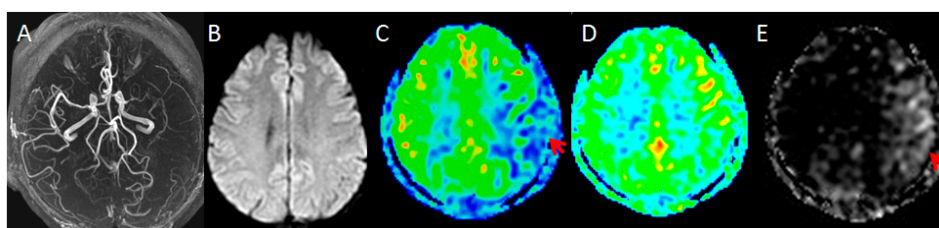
Left MCA with severe stenosis was showed on 3DTOF (A) in a 32-year-old asymptomatic patient. DWI (B) was normal. Hypoperfusion was noted on 3D pCASL with PLD 1.5 S (C, arrow) but normal on PLD 2.5 S (D). High signal on subtraction image between PLD 1.5 S and 2.5 S was clear may be indicated collateral perfusion (E, arrow).
